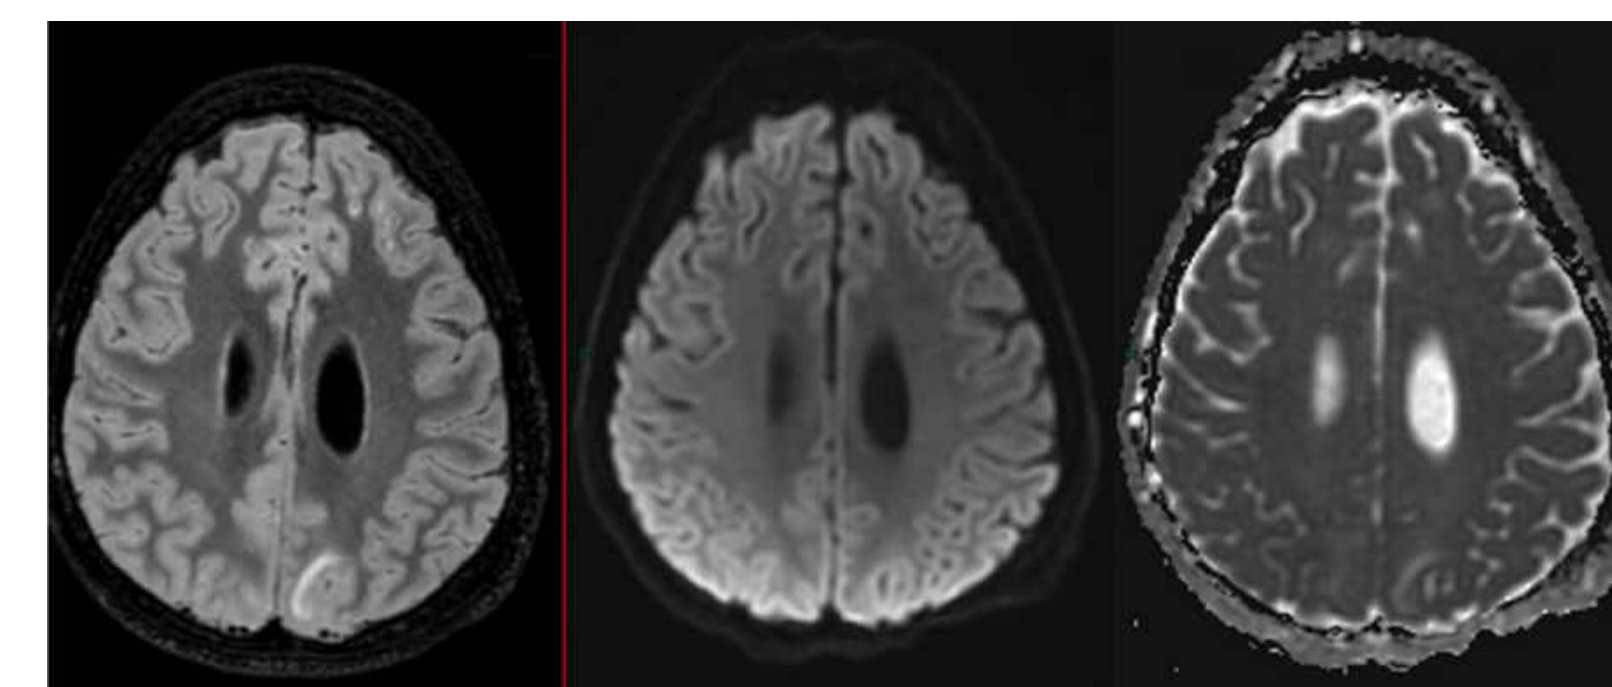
FLAIR-weighted MRI, DWI, ADC. Hypertensive lesions on FLAIR in left occipital subcortical and paramedian posterior parietal topography, without diffusion restriction.
